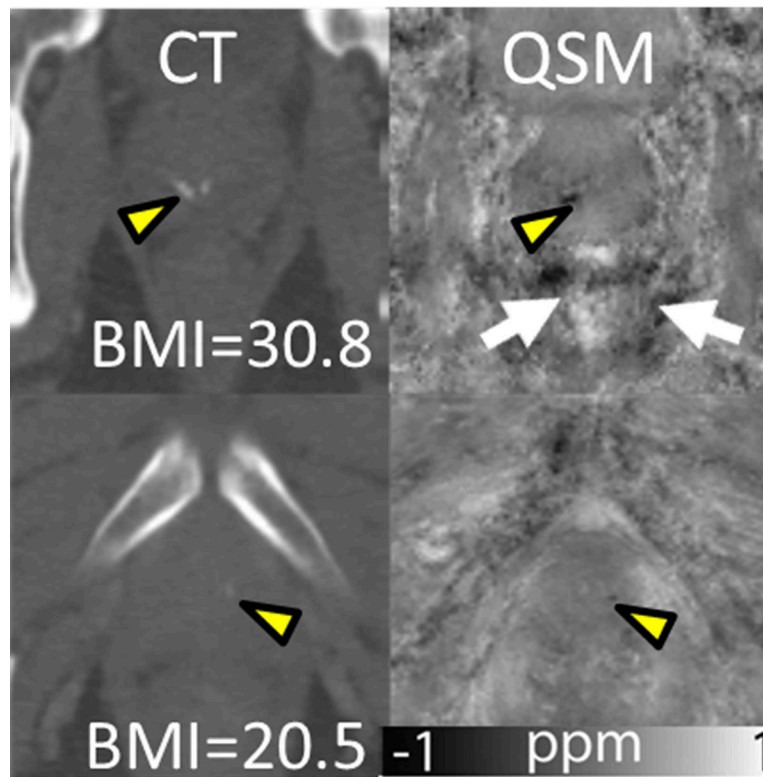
QSM in prostate. Prostatic calcifications (yellow arrowheads) in CT images (first column), and susceptibility maps (second column). Motion/air artifacts and noise can be observed around the prostate (first row), indicated by arrows. Additionally, body mass index (BMI) of patients is provided (adapted from (46)).
